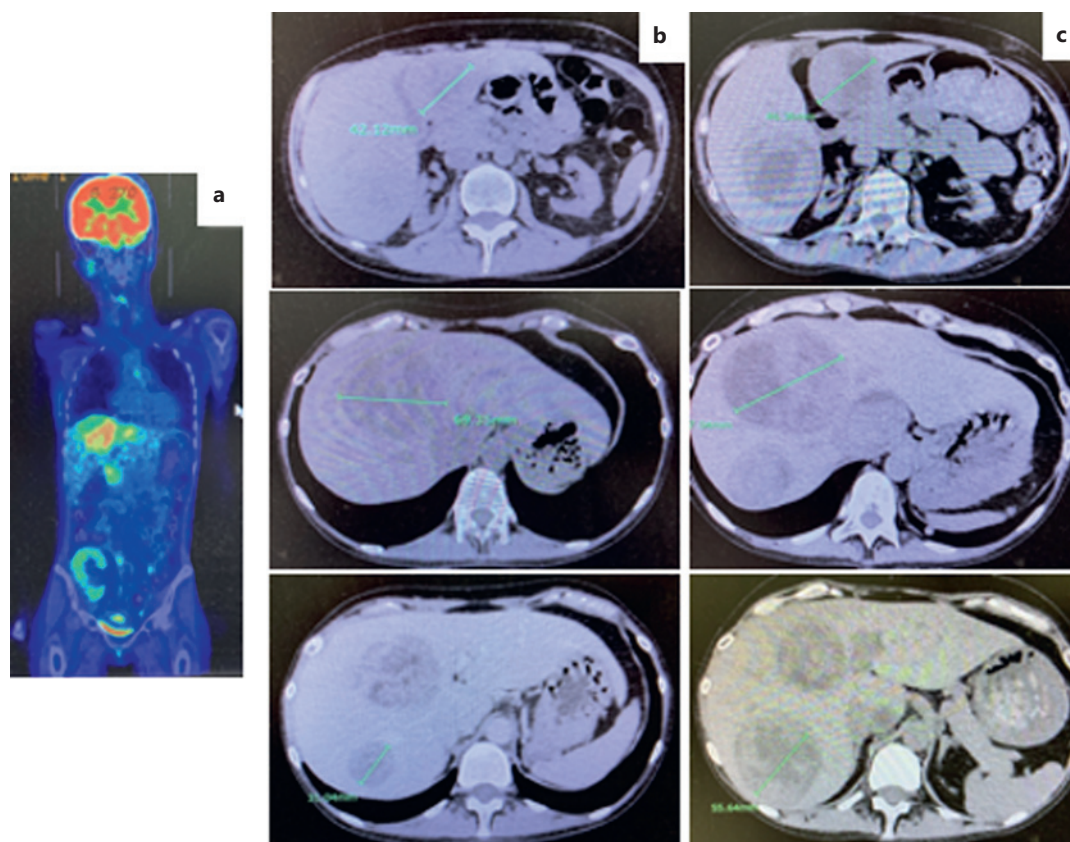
Changes in CT images of the EBV-SMTs in the lung and liver. a PET-CT image in July 2018. b CT images in July 2018. c CT images in January 2022.
